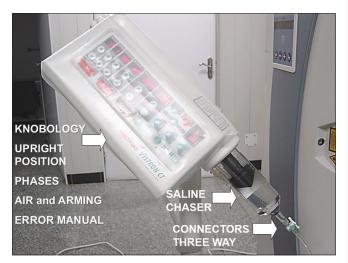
(A-E): Basic operational issues in pressure injectors (Medrad Vistron CT) include (A) working knowledge of phases, volume, rate, delay (B) an upright position during injection (C) arming after removal of air (D) a saline chaser that offers several advantages and (E) a correct handling of connectors and three way
